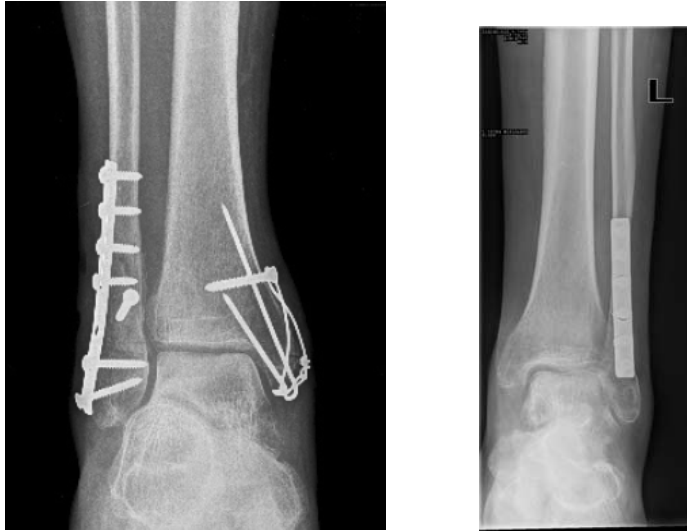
X-rays of ankle fractures fixed with metal. Visualisation of the fracture is obscured.
